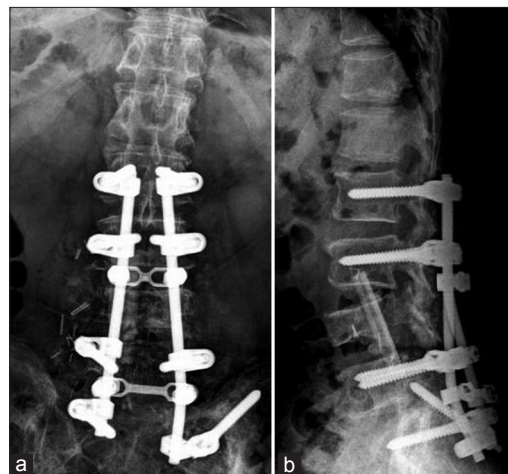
Anteroposterior and lateral radiographs of lumbar spine 7 months after surgical intervention: (a) anterior decompression with vertebrectomy of the fourth lumbar vertebral body and interbody fusion with structural fibula allograft and autologous bone graft; (b) posterior stabilization and fusion of L2–S1; note reduction of deformity and restoration of lordotic curve
